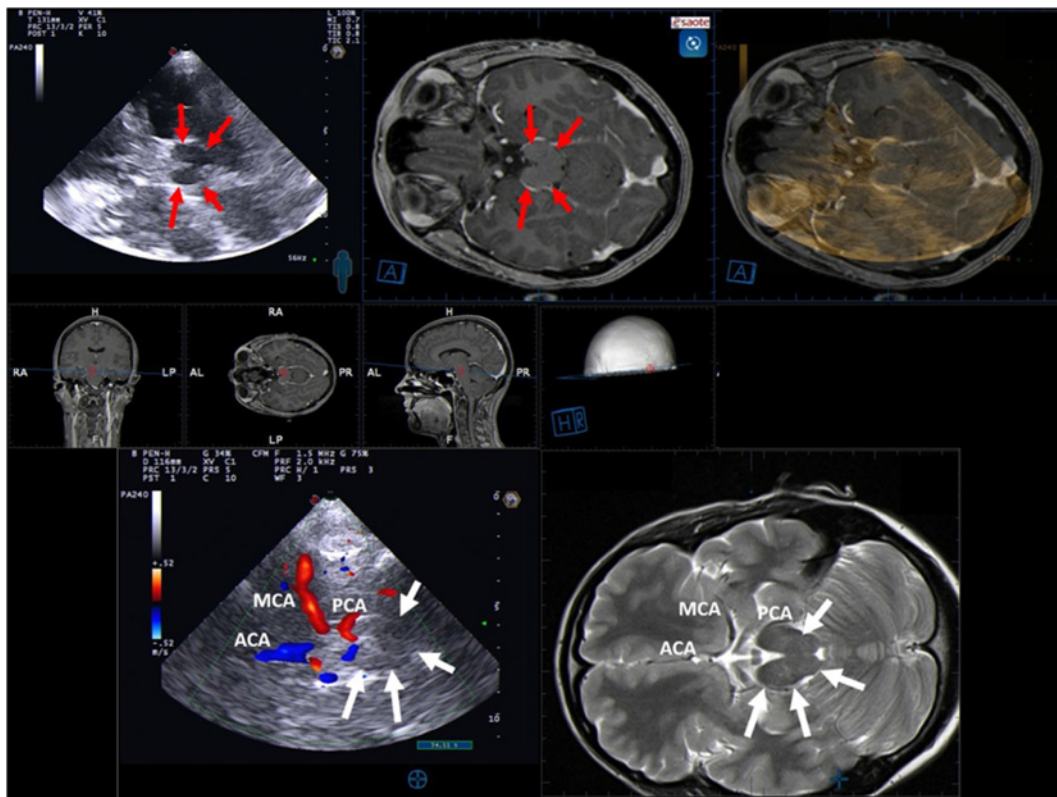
Top row: transtemporal insonation, axial imaging plane, and corresponding MRI and fusion image. Left: B-mode image of the midbrain-plane. Middle: corresponding T1-weighted post contrast MRI image. Right: Overlay image of both imaging modalities. Middle row: 3D-visualization of the chosen imaging plane and partial image of the 3D-surface rendering derived from the MRI dataset. Bottom row: Left: color-mode imaging of the basal cerebral arteries in excellent correspondence with the hypodense flow void signals of the MRI (right). Midbrain delineation = white arrows. MCA = middle cerebral artery, ACA = anterior cerebral artery, PCA = posterior cerebral artery.
